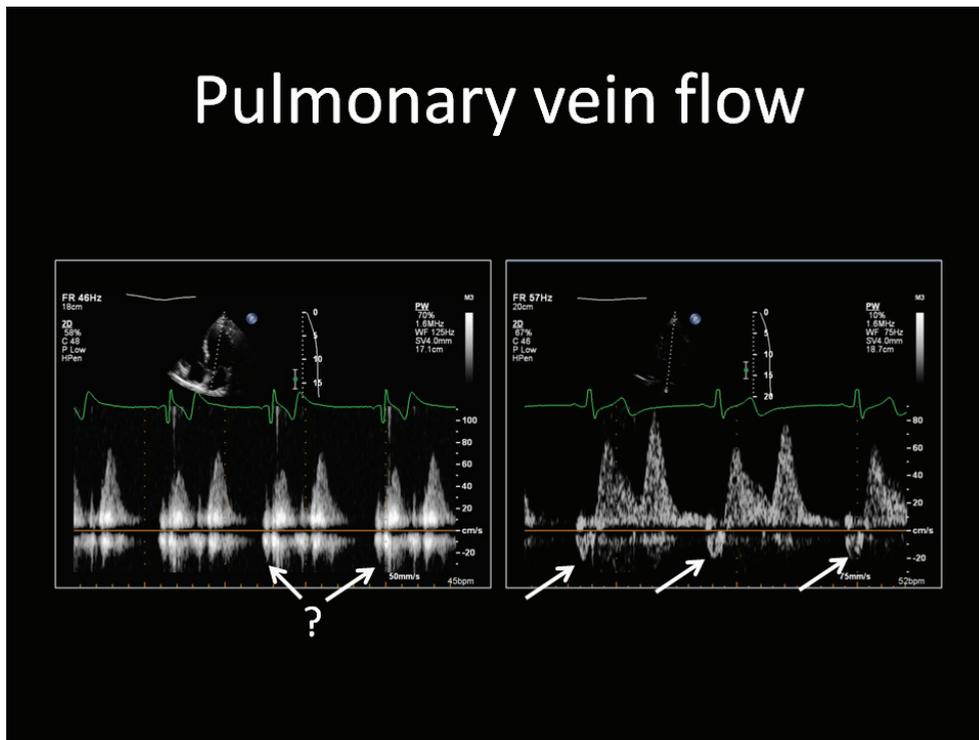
This is a different patient demonstrating the ability to use contrast to improve pulmonary venous flow assessment. Pulsed wave spectral Doppler display of pulmonary venous flow. Left. Unenhanced image with adequate tracing of the systolic (S) and diastolic (D) waves, but difficulty in discerning the atrial reversal (AR) velocity (arrow). Right. Contrast enhanced image with optimal spectral Doppler tracing confirming the AR maximal velocity is normal and  $<20\text{cm/s}$  (arrow)
